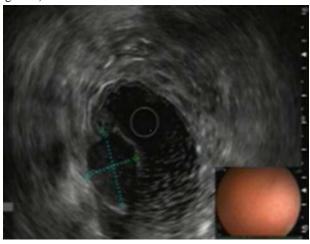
Endoscopic ultrasonography of the 25*19 mm lesion at lesser gastric curvature. This lesion occurred in the muscularis propria layer without any obvious lymph nodes, suggesting that it may be GIST
